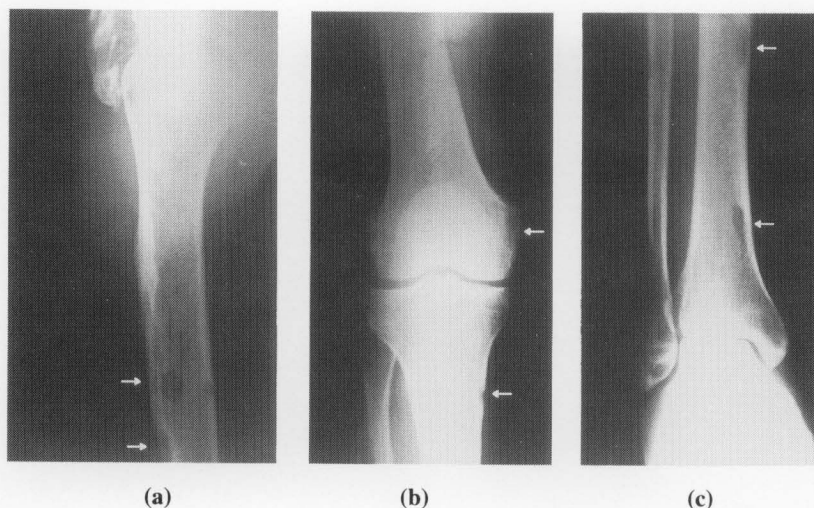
Radiographs of the right humerus (a), right knee (b) and left leg (c) showed multiple osteolytic lesions without sclerotic rim (arrows).
